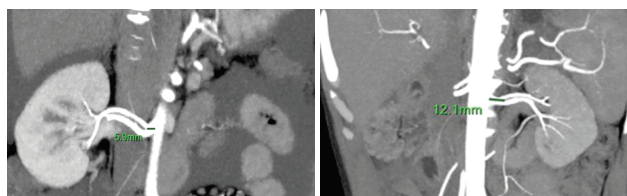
Curved coronal reformatted CT images showing early bifurcation of right (a) and left (b) renal artery.
